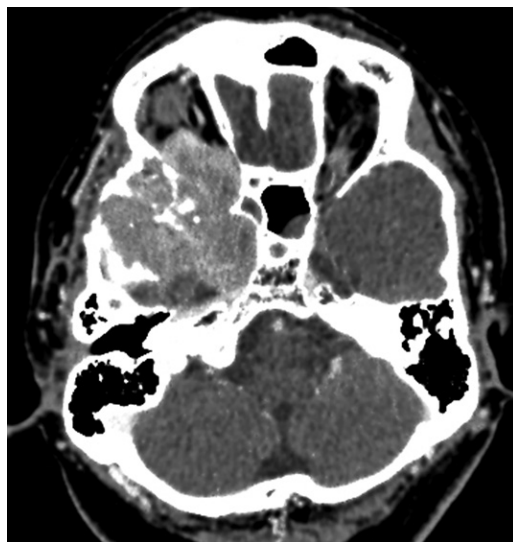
Atypical meningioma in a 47-year-old man with retinoblastoma who underwent enucleation of the left eye and RT (standard-fractionation type) of the right eye during childhood. Axial contrast-enhanced CT image shows a massive extra-axial tumor (atypical meningioma) in the right middle cranial fossa, extending into the right orbit and cavernous sinus with bone destruction.
